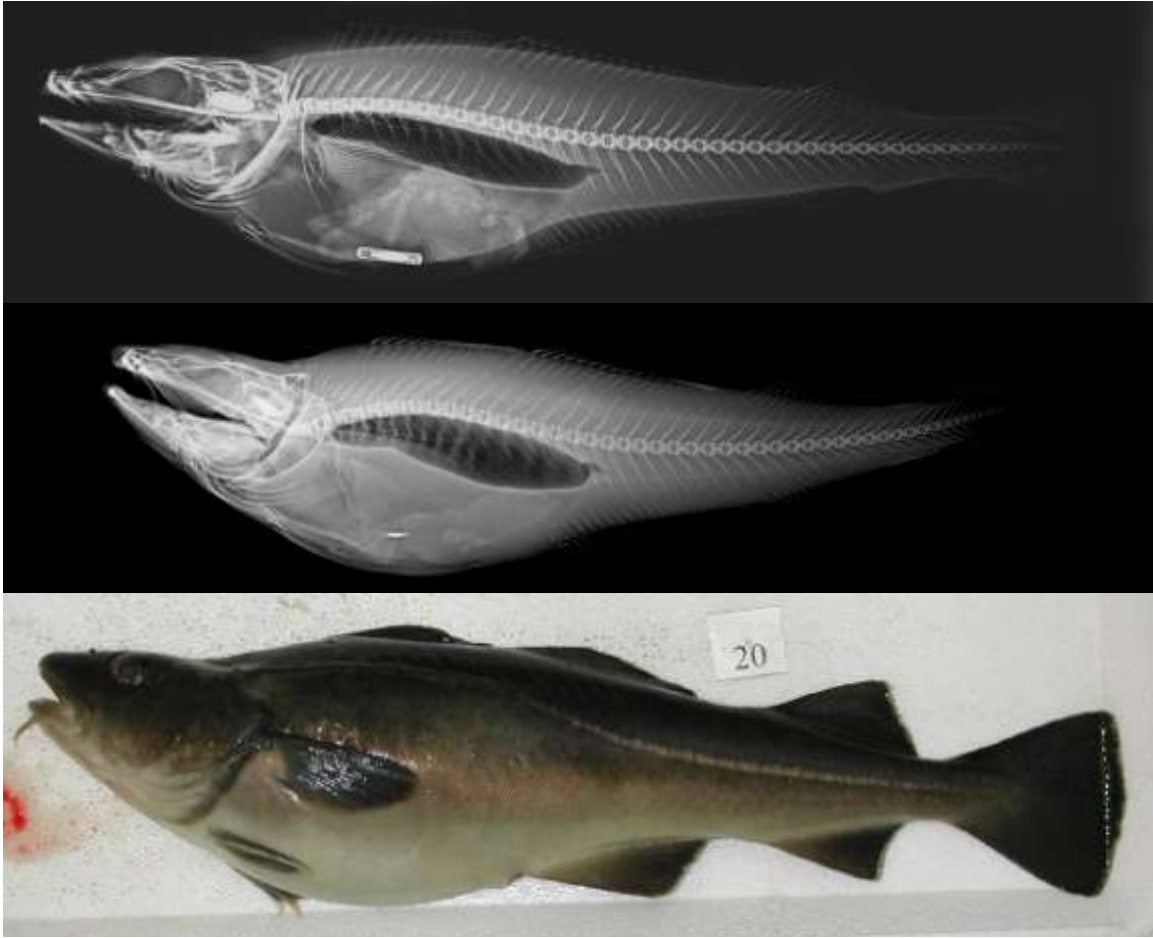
Development of pathology in neck vertebrae with time. Three images of the same individual. The top X-ray taken at transfer to seacage, approx. 50g size. The second X-ray was taken one year later, at approx 1 kg size, and demonstrates development from grade II to grade III. Lower photo shows external appearance of fish at 1 kg size.
